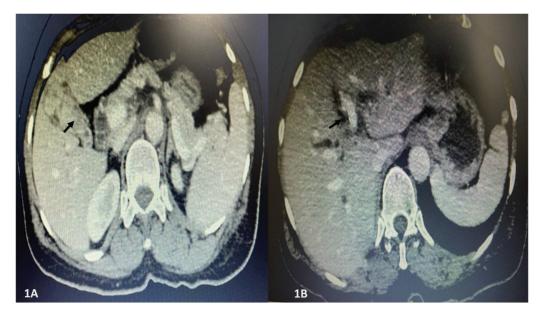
(A) Computed tomography abdomen and pelvis showing a heterogeneously enhancing lesion in the gallbladder lumen, causing irregular luminal obstruction (black arrow). (B) Dilated bilobar intrahepatic biliary radicals (black arrow).
